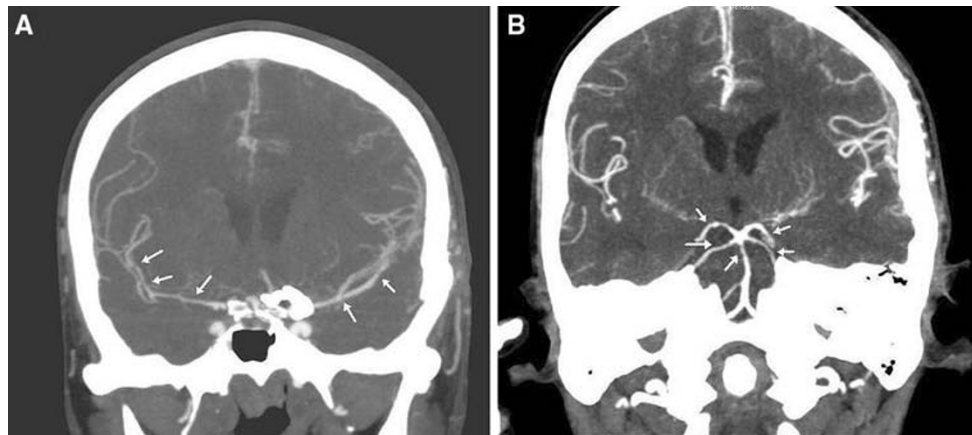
Angio-CT, three-dimensional reconstruction, coronal view. a Diffuse segmental stenosis of the proximal and distal (arrows) right middle cerebral artery. Segmental stenosis of the distal (arrows) left
